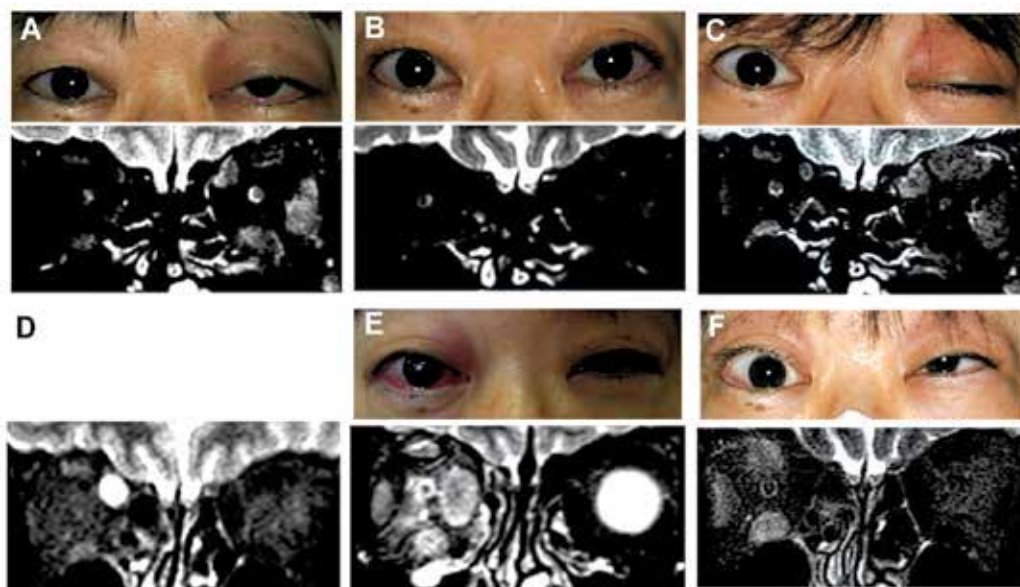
Chronic/recurrent type of ipathic orbital myositis. A 46-year-old woman with left periocular inflammation and ocular motility restrictions was referred to our hospital because her myositis was refractory to high doses of prednisolone with a slow taper. A: Fat-suppressed T2-weighted MR image at the initial examination shows hyperintense signals in the left inferior and lateral rectus, and superior oblique muscles. B: Following steroid pulse therapy, there is a complete recovery of the signs and symptoms. C: and D: and E: She received high dose steroid (prednisolone 60mg) with a slow taper, however the myositis recurred three times during the tapering. Note that more than one muscle including the right superior oblique muscle was affected. F: She developed a strabismus two years after the initial visit and had persistent ocular motility restrictions.
